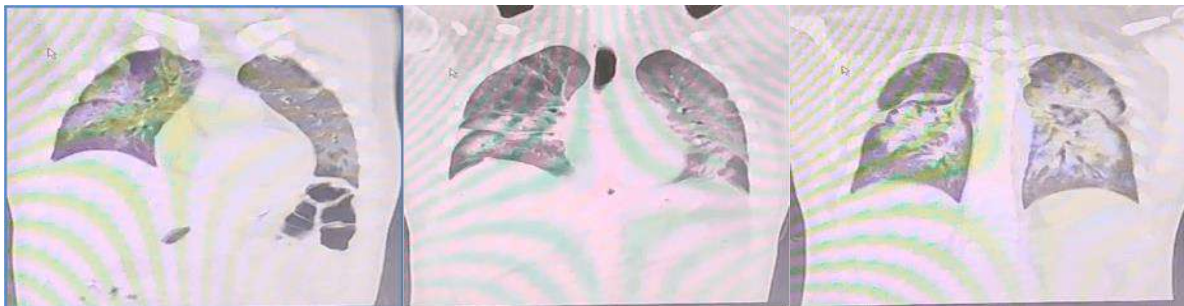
Chest CT scan of the patient's coronal cut
